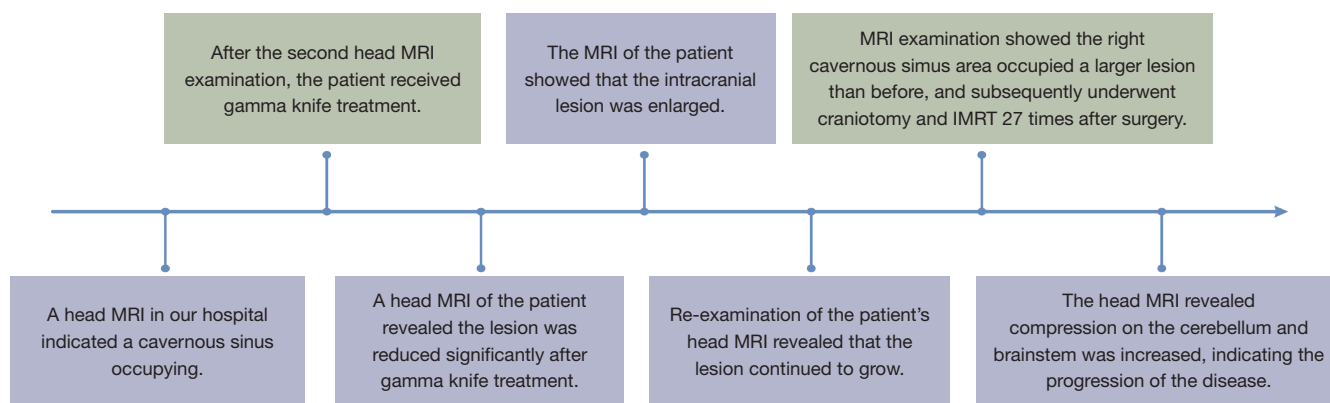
Timeline of the patient's treatment process. MRI, magnetic resonance imaging; IMRT, intensity-modulated radiation therapy.
